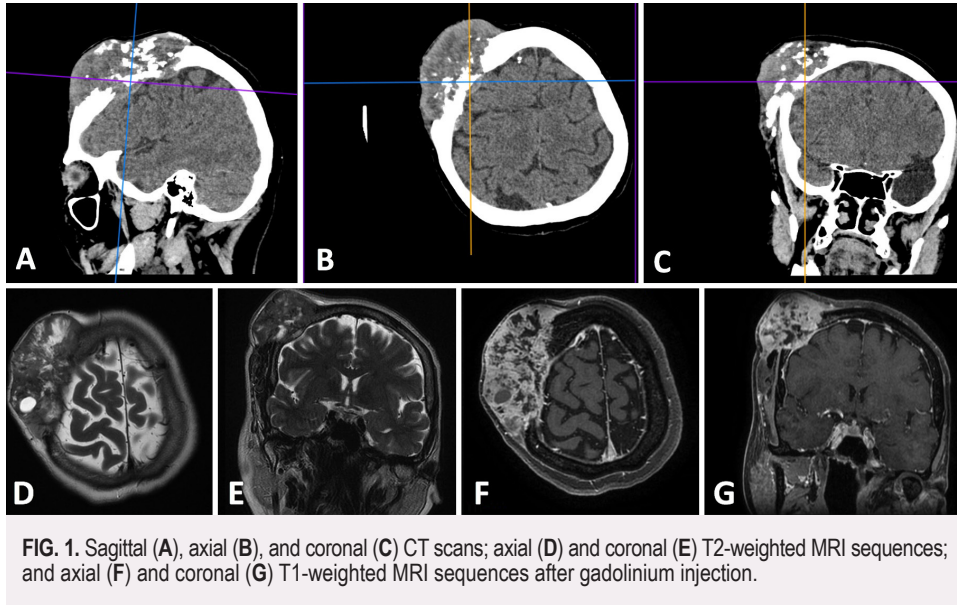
Sagittal (A), axial (B), and coronal (C) CT scans; axial (D) and coronal (E) T2-weighted MRI sequences; and axial (F) and coronal (G) T1-weighted MRI sequences after gadolinium injection.
